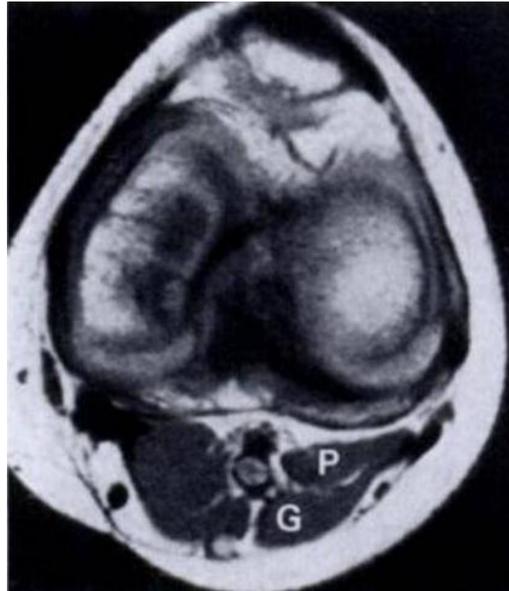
Axial proton-density-weighted MRI in a man, showing a normal plantaris tendon (P) at the knee. G=lateral head of the gastrocnemius muscle (Saxena and Bareither, 2000)
